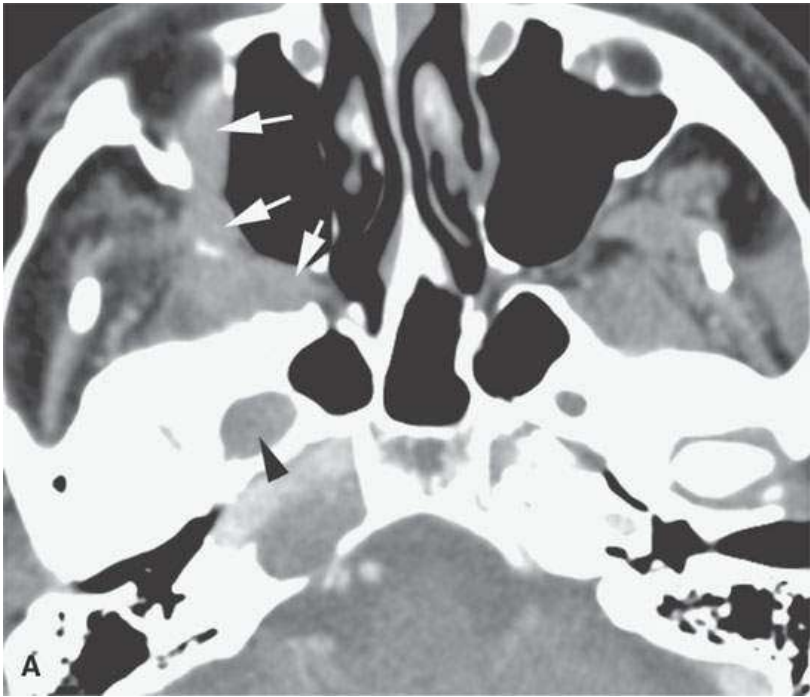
A patient with peripheral fifth and seventh cranial nerve weakness for over 1 year with two prior magnetic resonance imaging (MRI) studies interpreted as showing only a cavernous sinus mass; the patient was scheduled for a craniotomy. These following computed tomography (CT) and MRI studies done within a month of the latest prior study showed perineural spread of a neurofibrosarcoma along the fifth and seventh cranial nerves. The confirmatory procedure was changed to a percutaneous CT-guided biopsy, but open biopsy of the facial nerve was necessary for a complete final pathologic diagnosis. A: Contrast-enhanced CT shows tumor spreading along the facial nerve (*arrows*) to its junction with the auriculotemporal nerve and then along the mandibular division of the trigeminal nerve (*arrowheads*). B: Contrast-enhanced T1-weighted (T1W) image shows tumor spreading along the facial nerve (*arrows*) to its junction with the auriculotemporal nerve and then along the mandibular division of the trigeminal nerve (*arrowheads*). C: T2-weighted image shows tumor spreading along the facial nerve (*arrows*) to its junction with the auriculotemporal nerve and then along the mandibular division of the trigeminal nerve (*arrowheads*). Note that the tumor is about muscle equivalent in signal intensity—a finding unusual in epithelial perineural spread and related to the fibrous component in this neurogenic sarcoma. D: Contrast-enhanced T1W image shows the tumor to have spread to the trigeminal ganglion (*arrow*) and then antegrade along V2 to the foramen rotundum (*arrowhead*).
